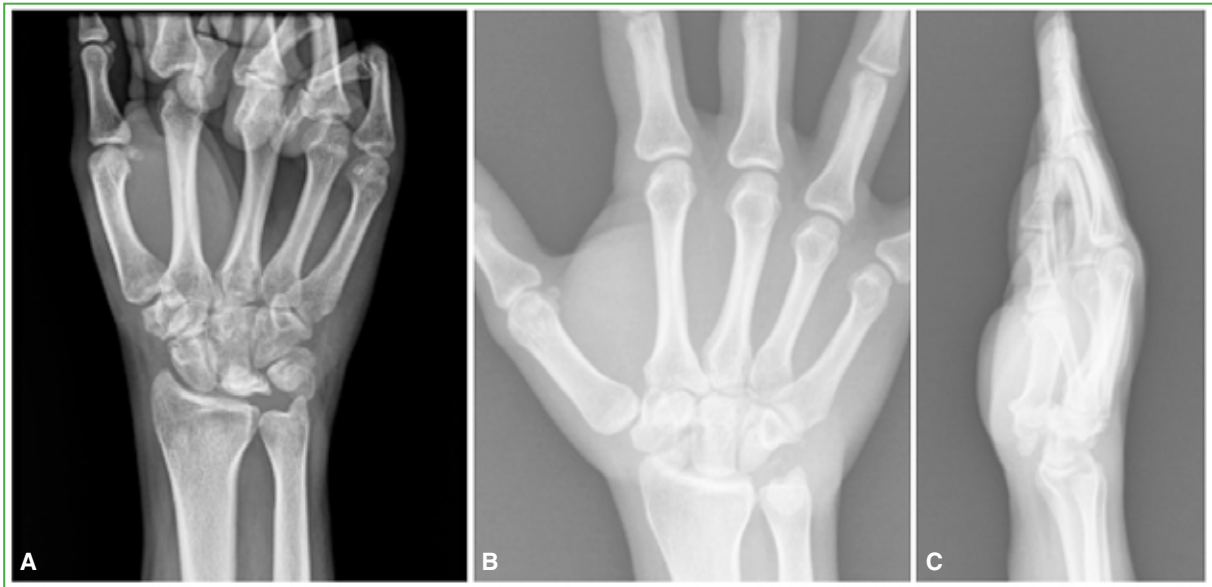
A. 26-year-old patient, manual worker, diagnosed with Kienböck's disease in the right hand. B. Anteroposterior radiograph of the right wrist, 7 years after proximal carpectomy. C. Lateral radiograph of the right wrist at 7 years of follow-up. Good clinical and radiographic evolution.
